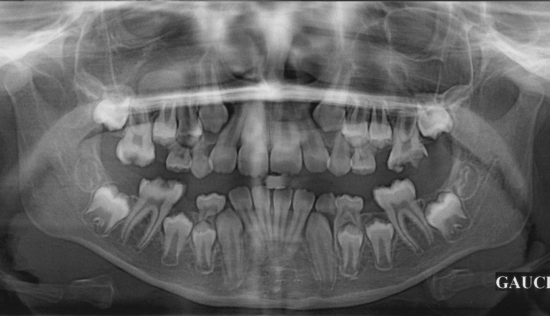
X-rays at completion of active treatment and cephalometric measurements.
